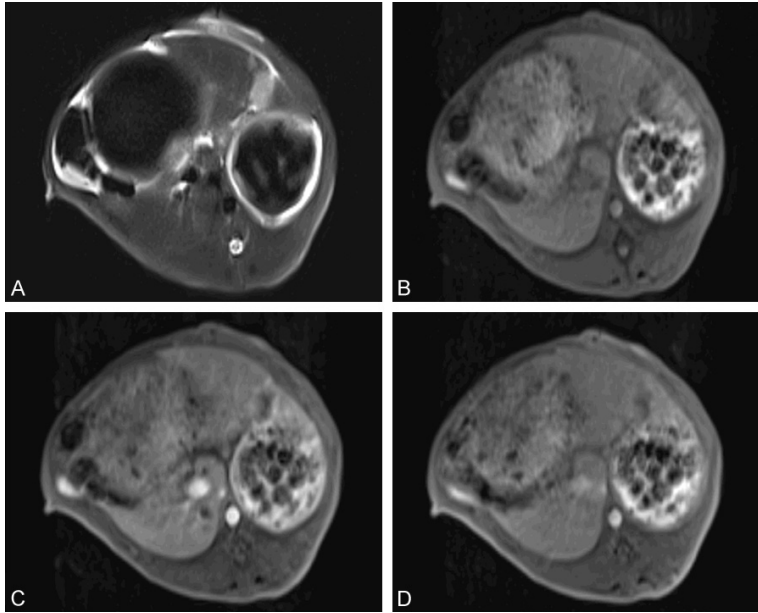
MRI detection of successfully implanted VX2 hepatocarcinoma. (A) T2-weighted images and (B) T1-weighted images: single intrahepatic nodules could see in figures. The T2-weighted images showed more distinct boundary than that of T1-weighted images. (C) T1-weighted enhanced images at the arterial phase: marked enhancement on implantation site showed a similar radiological performance to hepatocarcinoma. (D) T1-weighted enhanced images at the delayed phase: vanished appearances on implantation site were also similar to the performance of hepatocarcinoma.
